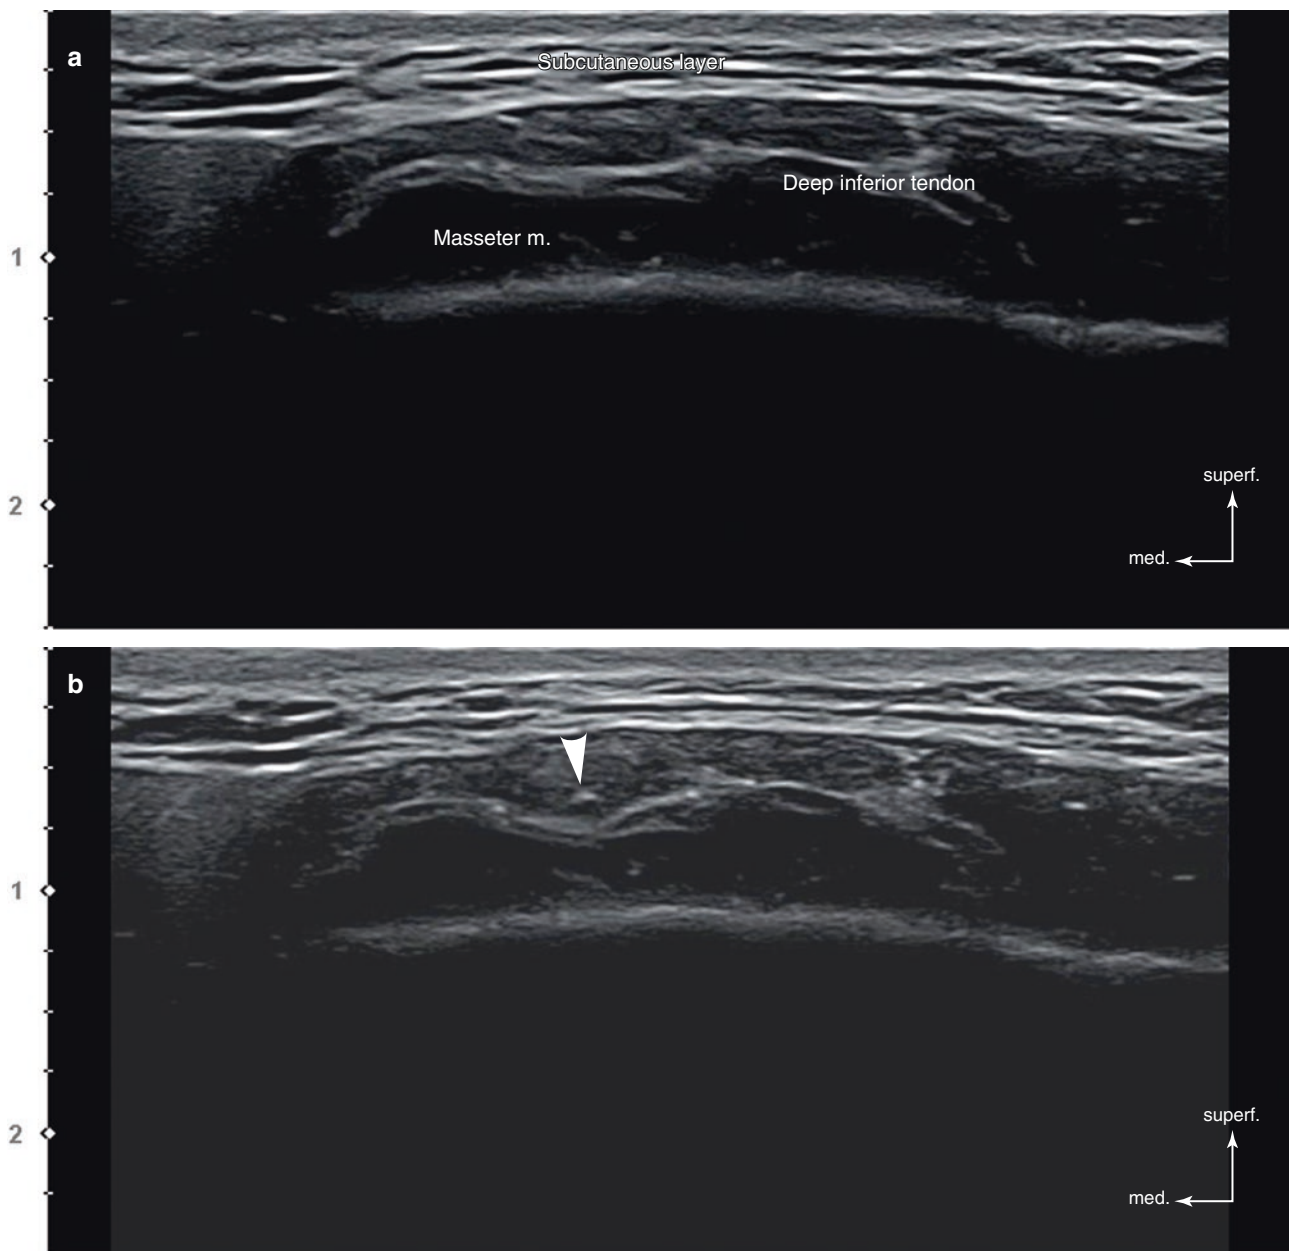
Ultrasonography-guided botulinum toxin injection to the masseter muscle. (a) Before injection, B mode (transverse view, 15 MHz by linear transducer) and (b) during injection (out-of-plane), B
